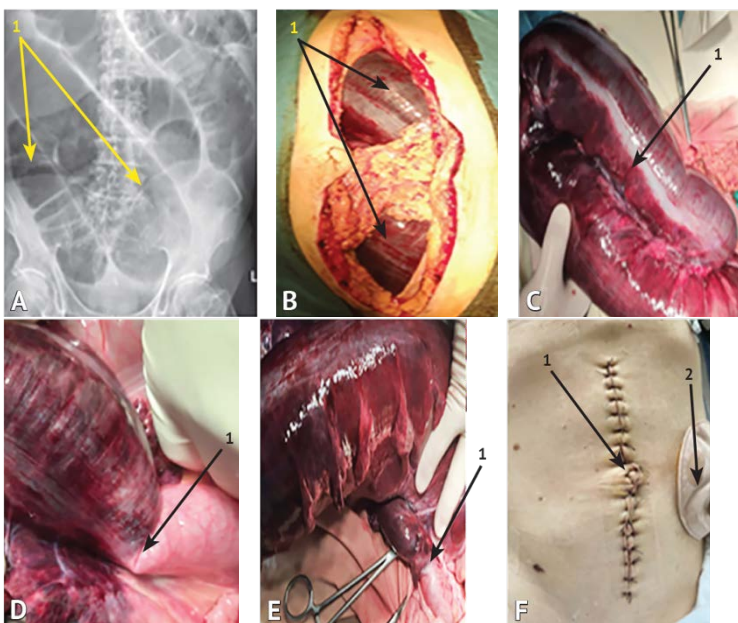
Volvulus, strangulation, necrosis of the sigmoid colon. A — plain X-ray of the abdominal cavity. Sharply swollen loops of the sigmoid colon are detected (arrow 1); B — laparotomy. In the abdominal cavity there are dilated loops of the sigmoid colon (arrow 1) with signs of ischemia and necrosis; C— intraoperative photo. The sigmoid colon with significant signs of occlusive disorder of the blood supply to the intestine and its necrotic changes (arrow 1); D— intraoperative photo. The volvulus site with demarcation line (arrow 1); E— intraoperative photo. The volvulus site with demarcation line (arrow 1); F — the view of the postoperative laparotomy wound (arrow 1) and end sigmoidostoma with colostomy bag (arrow 2)
